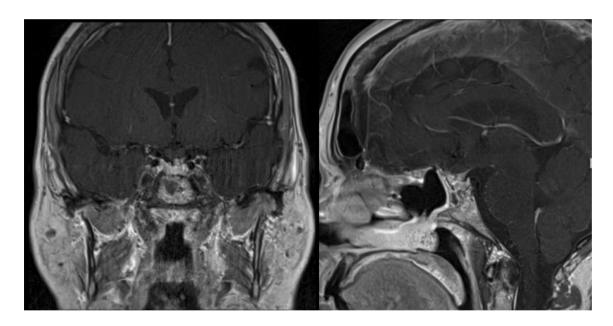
Post-operative coronal (*left*) and sagittal (*right*) post-gadolinium T1-weighted magnetic resonance imaging of anterior skull base meningioma
